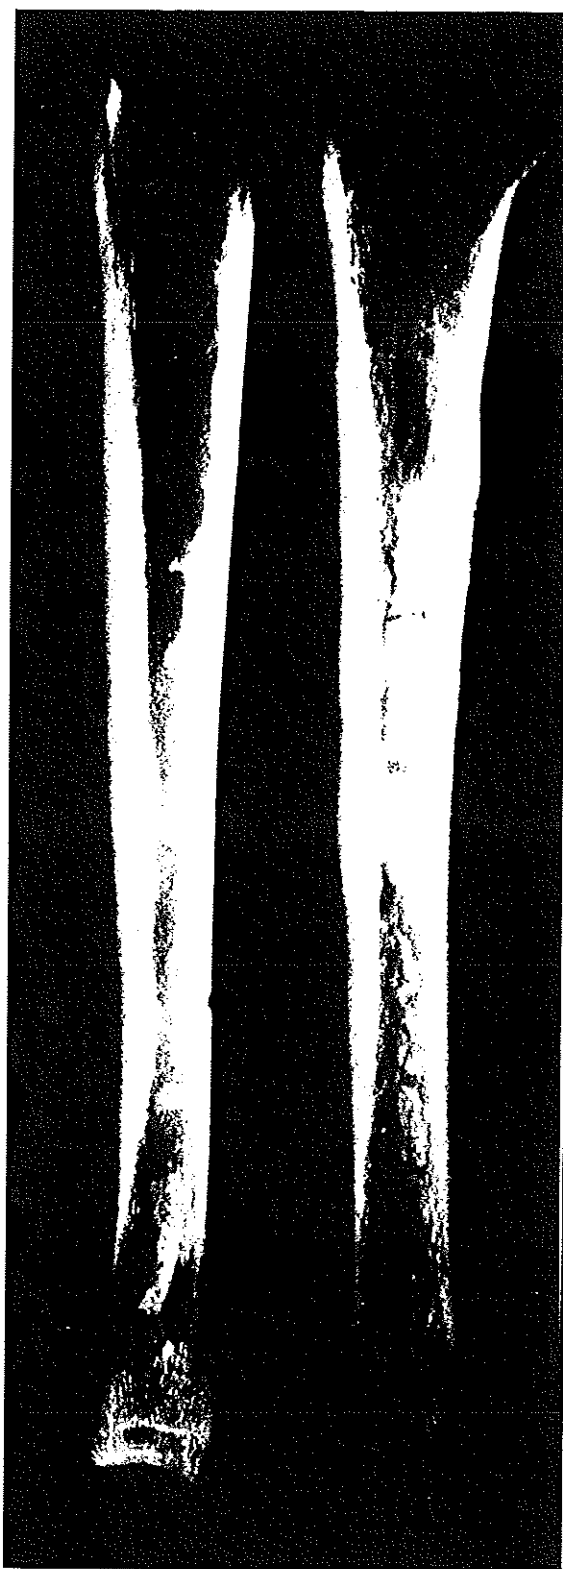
Radiograph of tibia from 770 showing cortical thickening and periosteal new bone growth.
